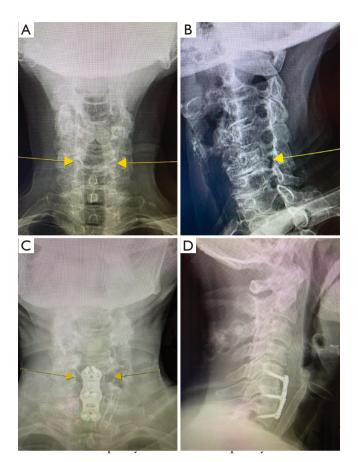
Preoperative and postoperative cervical X-rays demonstrating the results of anterior cervical uncinectomy. Preoperative AP (A) and oblique (B) X-rays demonstrate uncinate hypertrophy at C5–6 (arrowheads) with associated bony foraminal stenosis. Postoperative AP (C) X-rays demonstrate complete uncinectomy (arrowheads) with bilateral foraminal decompression and intact ACDF graft and plate construct (D).
